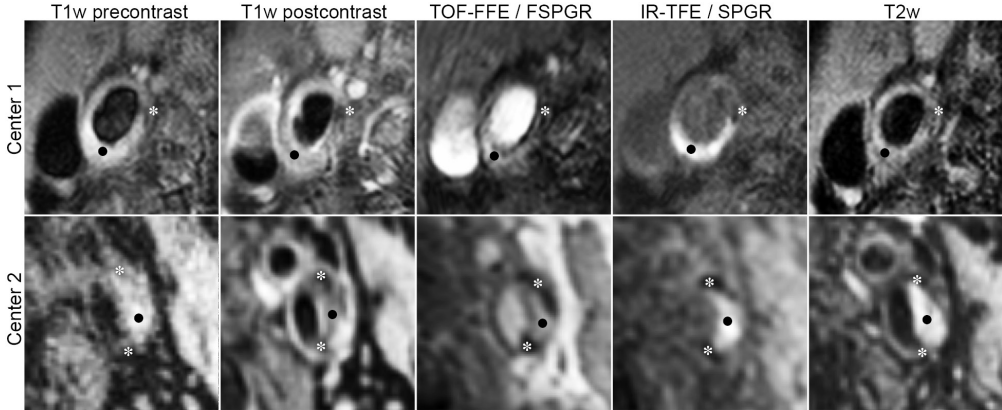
Examples of registered MR images from both centers. Center 1: A calcium spot (*) is indicated, which appears hypointense on all sequences. A region of IPH (black dot) is hyperintense on the IR-TFE sequence, TOF-FFE, and T1w precontrast, and shows no signal enhancement on the postcontrast T1w image. Center 2: a hyperintense region on the SPGR and T1w precontrast scan indicates IPH (black dot), and is hypointense on the T1w postcontrast scan. Two hypointense regions of calcification (*) are visible in especially the FSPGR and SPGR scans.
